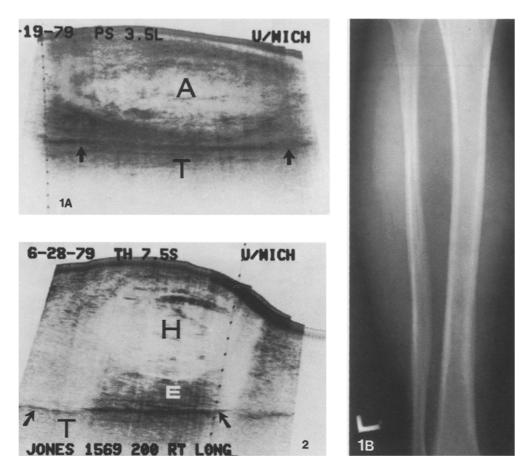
A and B. Case 3. Abscess. 53-year-old diabetic man with calf pain and swelling. A Sagittal scan through posterior aspect of lower extremity showing irregular sonolucent mass (A) with internal echoes of varying intensity. Percutaneous aspiration under ultrasonic guidance was diagnostic. Arrows point to posterior cortex of tibia (T). B Anteroposterior radiograph demonstrates mild soft tissue swelling of calf
